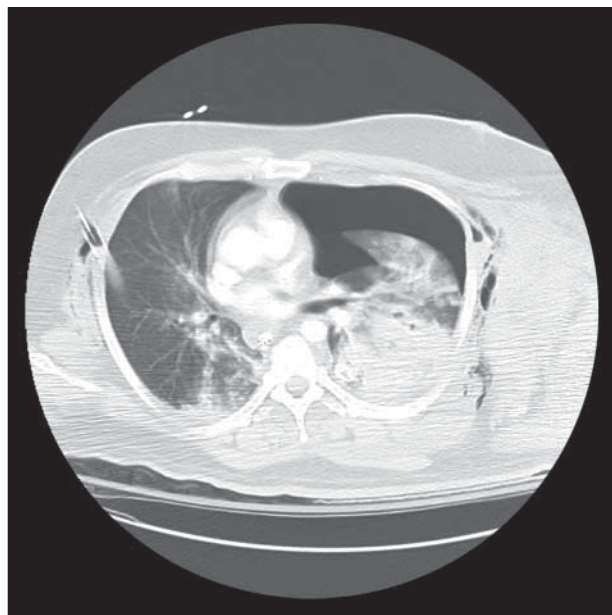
Computed tomographic image of a large residual tension occult pneumothorax with mediastinal shift to the right.
